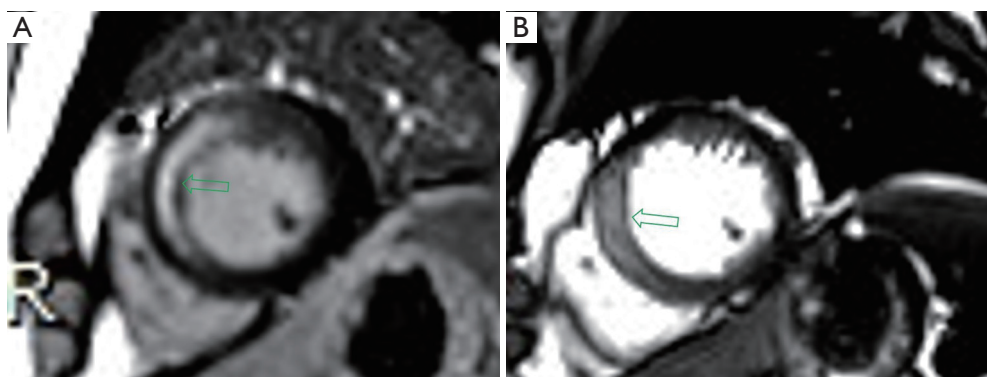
A 40-year-old male patient with STEMI. (A) Short axial LGE-MR image shows delayed enhancement area within the septal wall of ventricle (arrow), which is interpreted as MI without MVO. (B) Short axial cine CMR image at corresponding slice of (A) shows slight diffusion increase signal at the septal wall of ventricle (arrow). The 5 radiomic measurements (shape maximum 2D diameter slice, first order mean, GLSZM gray level non-uniformity, Gldm large dependence high gray level emphasis, and Ngtdm strength) are 0.24, 0.23, 0.57, -0.60, -0.94, respectively. The radiomic score is -0.09. STEMI, ST-segment elevation myocardial infarction; LGE-MR, late gadolinium enhancement-magnetic resonance; MI, myocardial infarction; MVO, microvascular obstruction; CMR, cardiac magnetic resonance.
